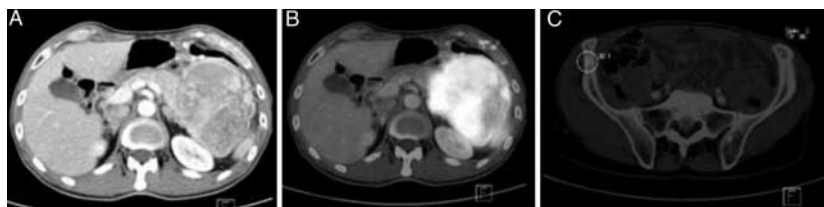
Abdominal CT of a 62-year-old patient with a 20 cm pancreatic neuroendocrine tumor (A). ^{68}Ga -DOTATOC PET/CT confirmed the location and dimensions of the primary lesion (B) and in addition disclosed a solitary bone metastasis (C). The skeletal deposit was identifiable only on the PET sequence.
